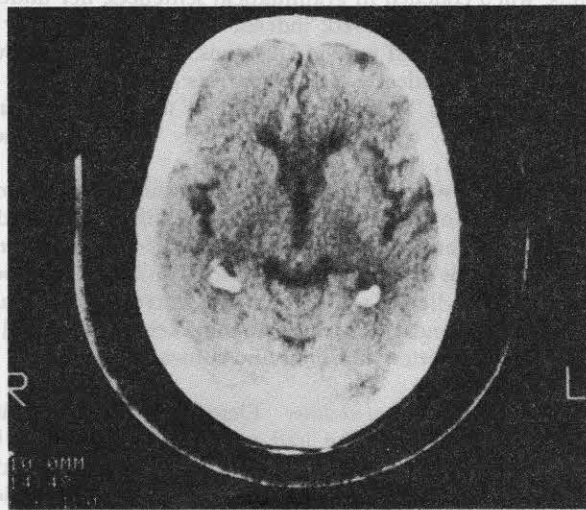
Computed tomogram of patient 2. There is cerebral atrophy, with widening of the sylvian fissures, greater on the left.
